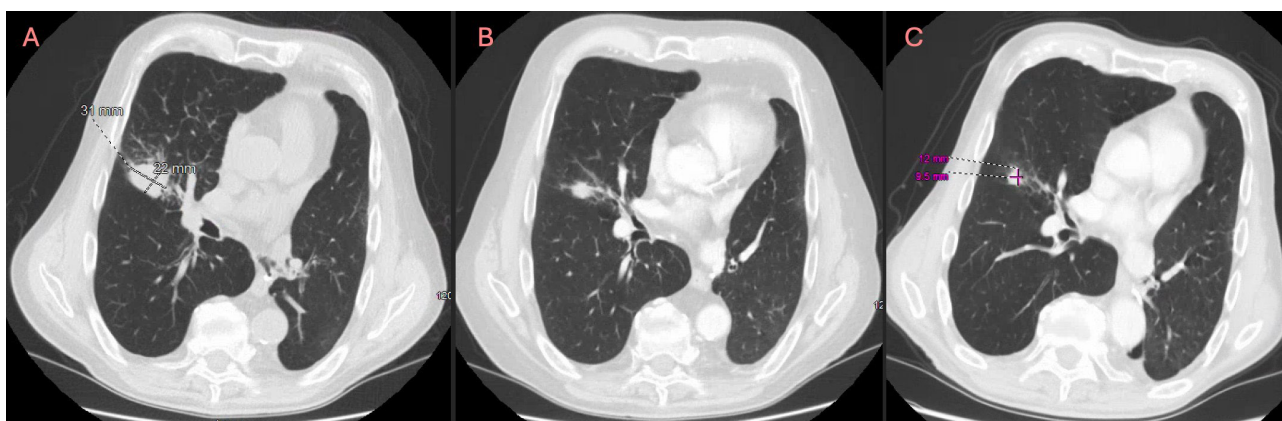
A) Computerized tomography (CT) scan of the chest showing a 3.1 x 2.2 cm mass in the right middle lobe suggestive of relapse of lung adenocarcinoma; B) Repeated CT scan after 5 months of brigatinib therapy showing decrease in size of lung mass; C) Latest CT scan after patient had been off brigatinib for 8 months showing continued partial response in lung mass.
